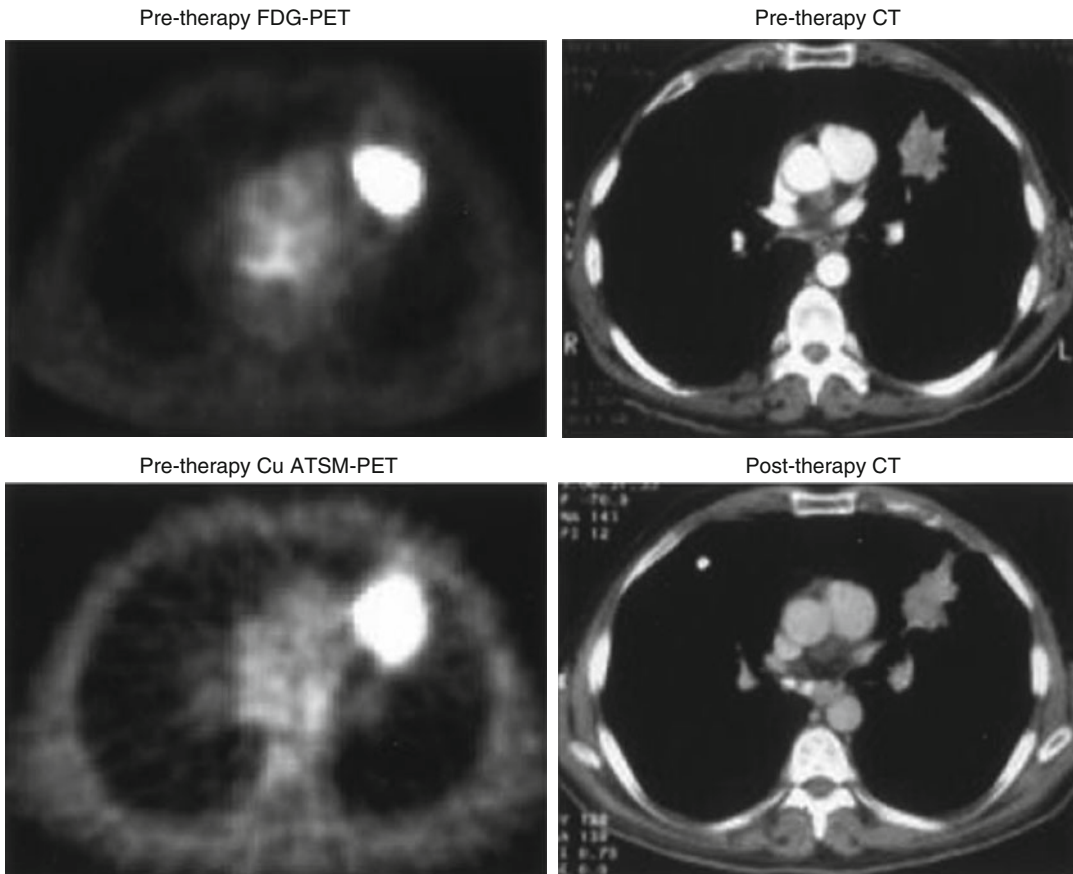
Feasibility of $[^{60}\text{Cu}]\text{ATSM}$ in clinical imaging of NSCLC for predicting the response to therapy. The pre-therapy $[^{18}\text{F}]\text{FDG}$ -PET scan (*upper left*) and the CT scan (*upper right*) of this NSCLC patient representing the results of a nonresponder confirm the existence of the tumor in the lingular mass. The uptake of $[^{60}\text{Cu}]\text{ATSM}$ was analyzed prior to therapy using PET scan (*lower left*) and compared to tumor response to therapy. Nonresponders had a
